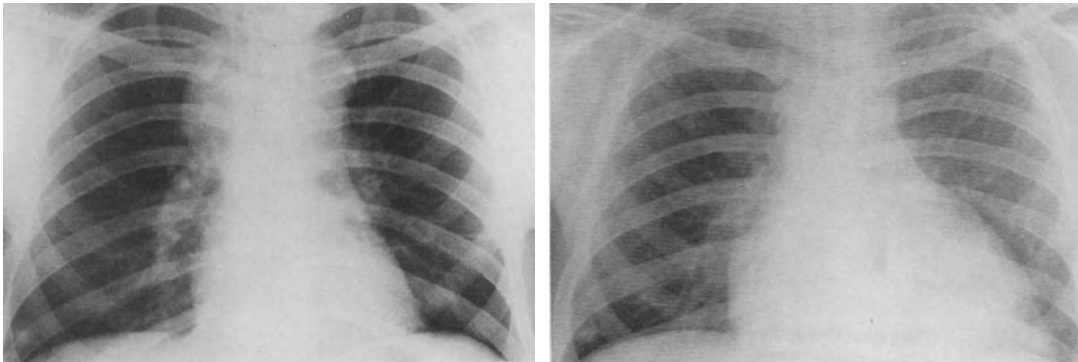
Chest X-rays demonstrating pericardial effusion in a case of Hodgkin's disease (left) before and (right) after pericardiocentesis. Following
